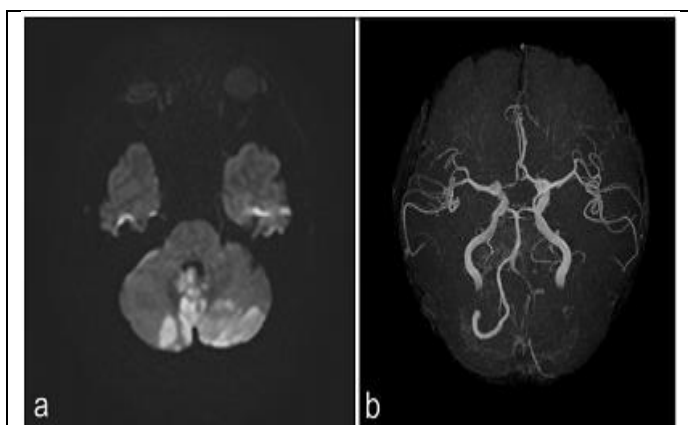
(a) Bilateral cerebellar infarctions were identified by initial head magnetic resonance imaging (MR). (b) The left V4 segment of the vertebral artery (VA) is not seen on the MR angiography.
